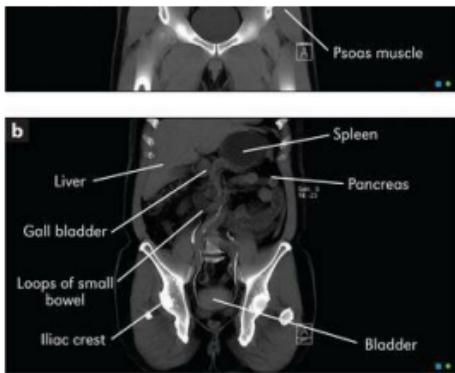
MRI scans of the abdomen
